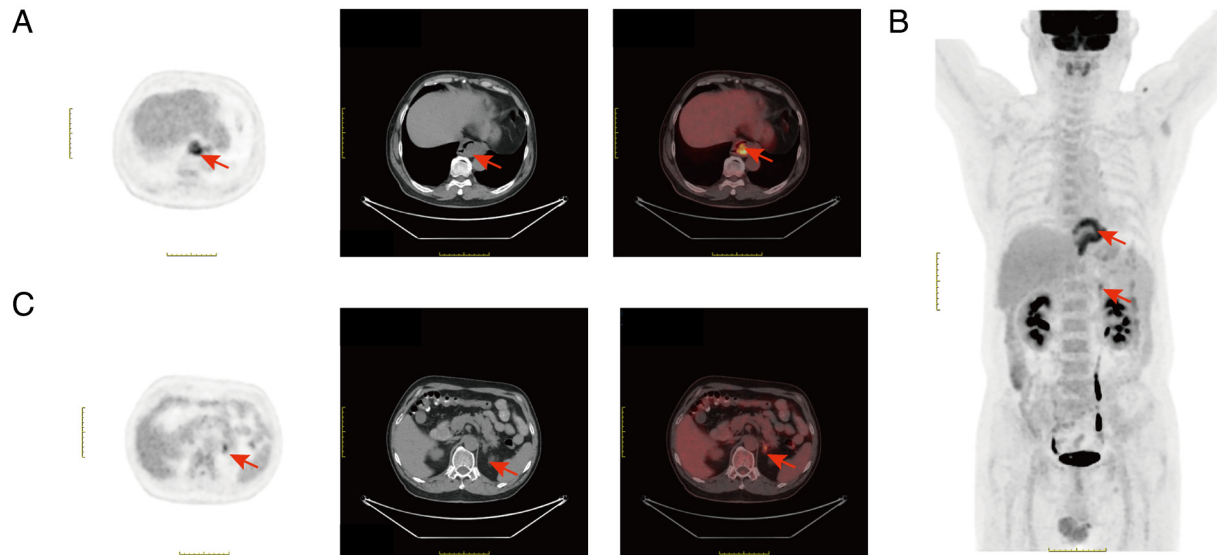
PET/CT imaging of esophageal leiomyoma and adrenal cortical adenoma. (A) The PET/CT images show a large, intensely 18F-fluorodeoxyglucose avid lesion in the esophagus (arrow), with a maximum standardized uptake value of 6.5. The corresponding CT images depict the abnormal mass in each organ. (B) Arrows point to the hypermetabolic lesions on the PET image. (C) A markedly hypermetabolic lesion can be observed in the adrenal region (arrows). PET/CT, positron emission tomography/computed tomography.
